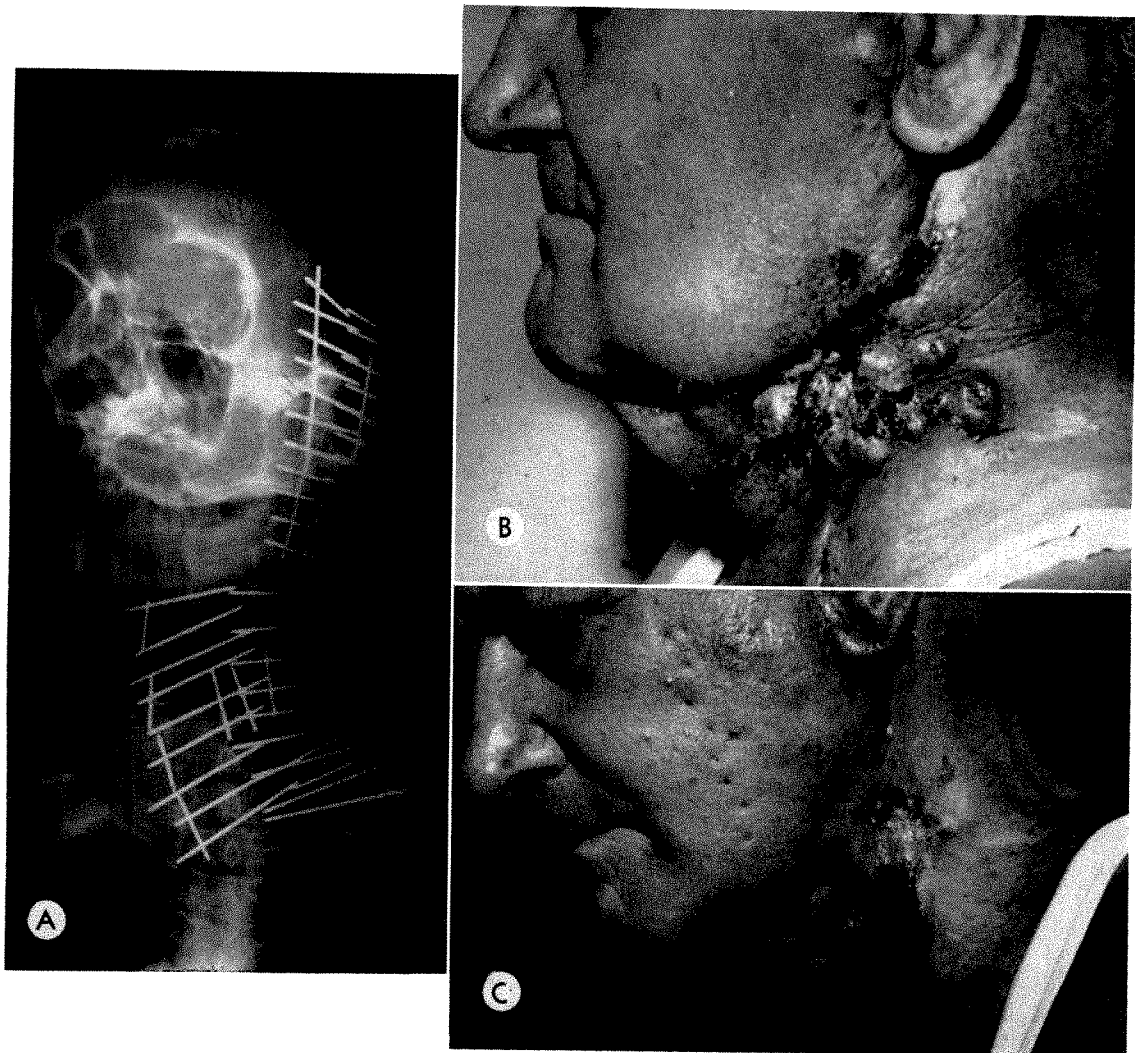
C.B. 58 W M. *Squamous cell carcinoma of the left side of the neck with left preauricular lymph node metastases, recurrent after radical neck dissection.* The primary lesion in the buccal mucosa, previously treated by irradiation (conventional roentgen rays and interstitial radium), was under control. The disease infiltrated the whole left side of the neck from mastoid to clavicle. Only interstitial radium implantation was performed.
